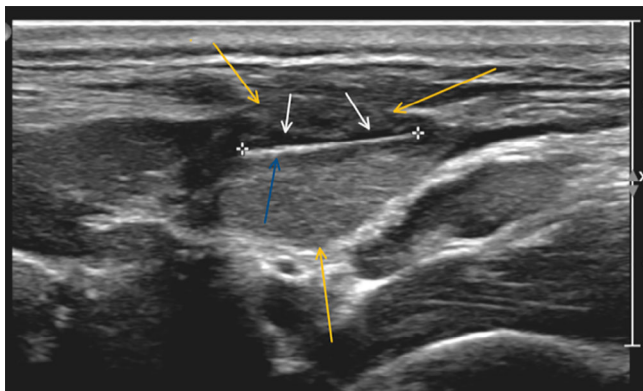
Ultrasonographic image of the right mandibular salivary gland (outline depicted by yellow arrows). Foreign body within salivary gland (blue arrow). Small pocket of anechoic fluid (white arrows).
